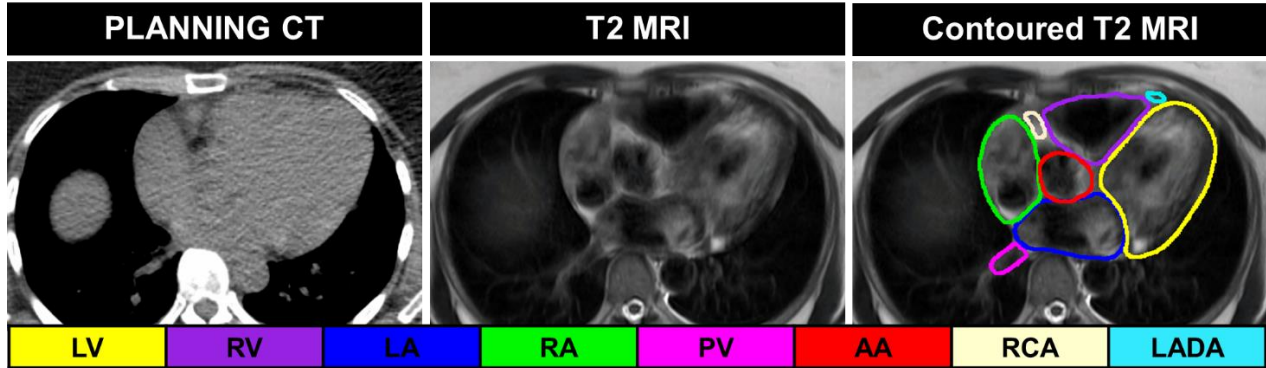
Left: Axial planning CT, Middle: Axial T2 MRI, Right: Contoured axial T2 MRI. Delineated substructures are outlined across the bottom with abbreviations defined in the text.
